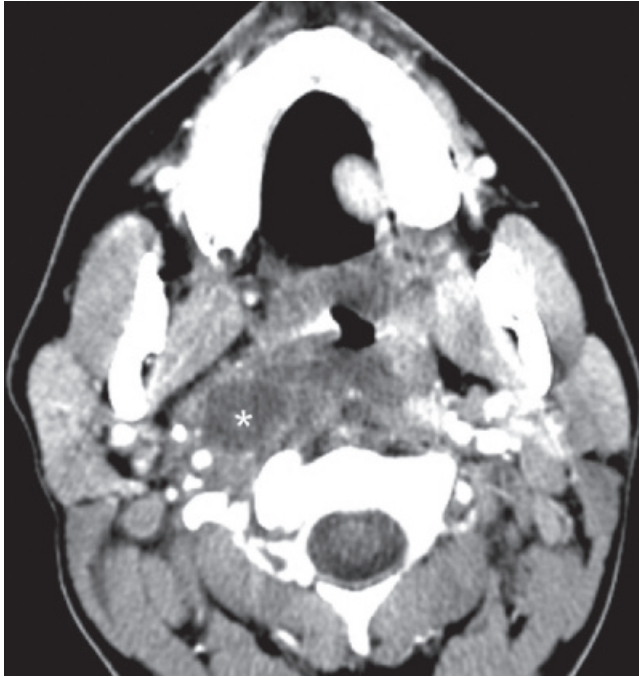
Retropharyngeal abscess. Axial contrast-enhanced CT shows a round abscess (asterisk) with an enhancing rim in the lateral retropharyngeal space. There is substantial surrounding edema. A lateral abscess such as this is likely the result of a suppurated node, whereas medial collections arise from direct inoculation.
